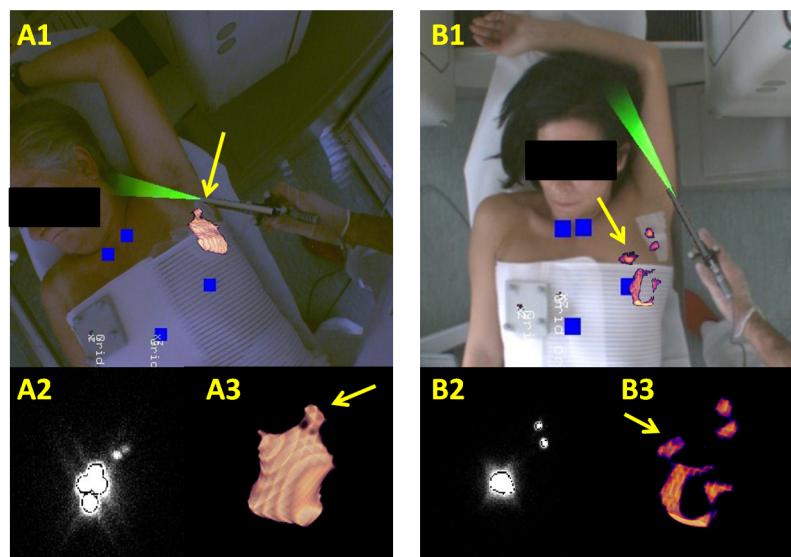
(A) Case where freehand SPECT was unable to tell apart between SLN (arrow) and injection site. In (A1) the augmented reality view shows however that despite the proximity of the node and the injection site, the image is clinically usable. Image (A2) confirms the proximity in the planar scintigraphy. (A3) shows how the node can be to some extent distinguished. In (B) a case of an evident artifact is shown. Near the two true SLNs a hot spot (arrow) is seen medially in close proximity to the injection site. Such artifact is clearly not an SLN, however cannot be really attributed to the injection site as seen in the planar scintigraphy (B2) and the 3D view (B3).
